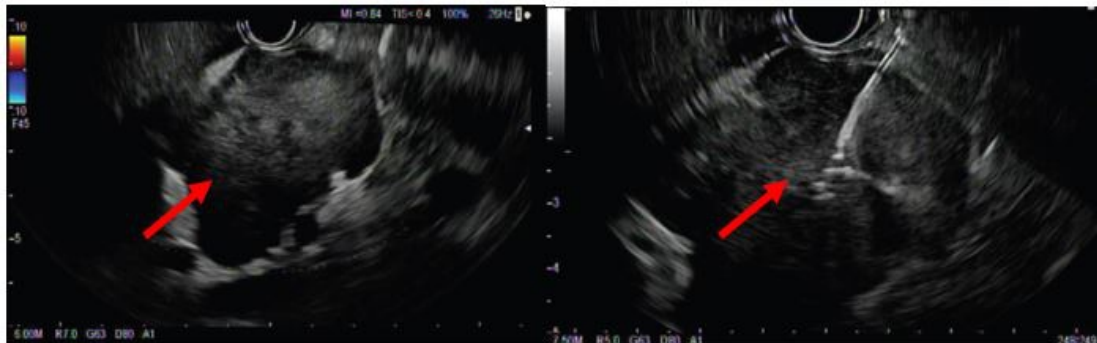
Endoscopic and endoscopic ultrasound appearance of Gastric Schwannoma
